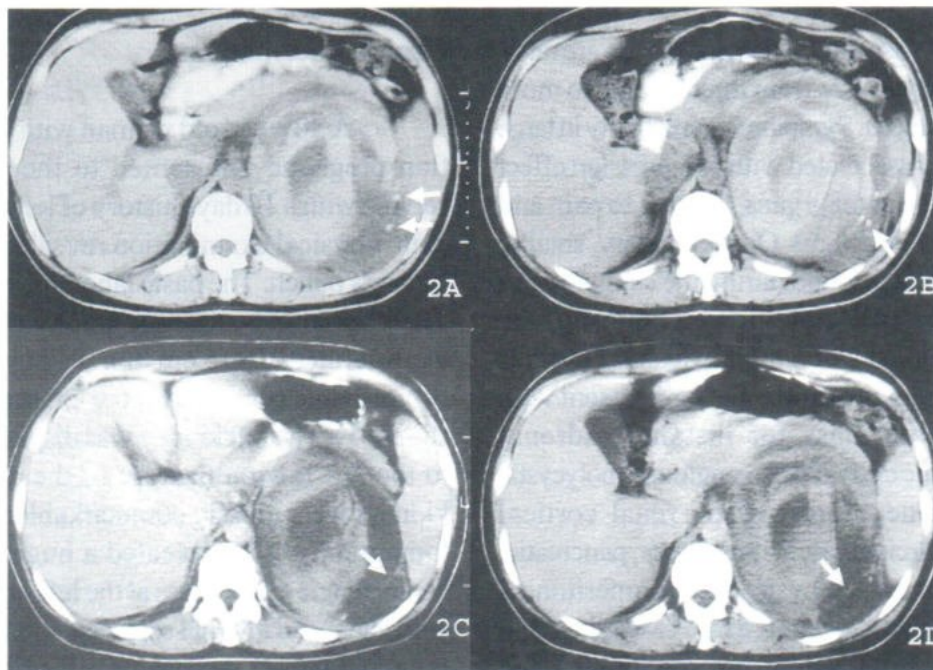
(A and B) Non-enhanced CT scan through left suprarenal region shows a large heterogeneous mass at the left suprarenal region with anterior displacement of the pancreas. The high attenuation areas consistent with hemorrhage. Calcifications in the wall of the mass (arrows) are shown. (C and D) Contrast-enhanced CT scan shows a well-delineated internal septae.
